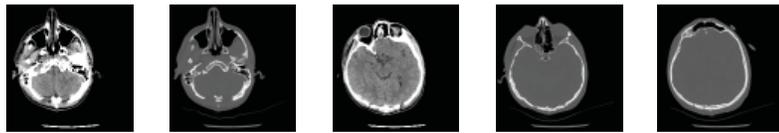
Follow up CT Brain done in the 1st post-operative day. (a) Both retro cerebellar hematomas were adequately evacuated and in the bone window you can see the size of craniectomies done and the bone ridge left in between. (b) Both occipital hematomas were also completely evacuated and in bone window the 2 small craniotomies were made few millimeters away from the midline
